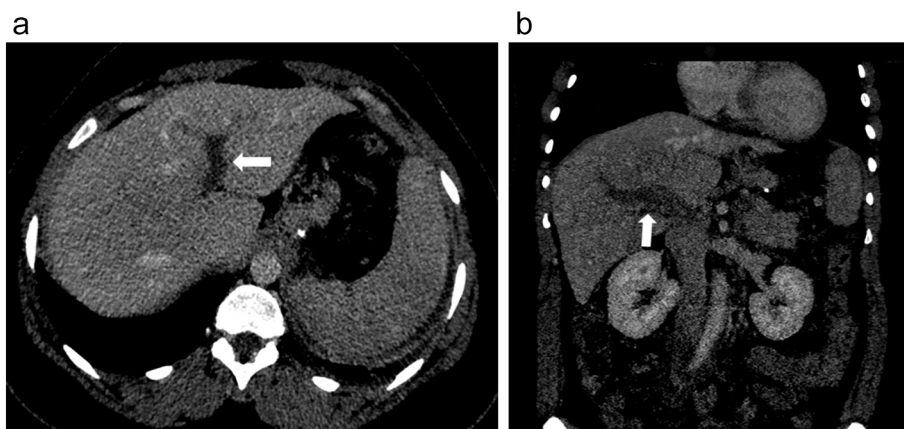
a. Contrast enhanced CT scan abdomen Porto venous phase axial view demonstrating complete obstruction of the intrahepatic venous tract, no cavernous formation seen (arrow).
